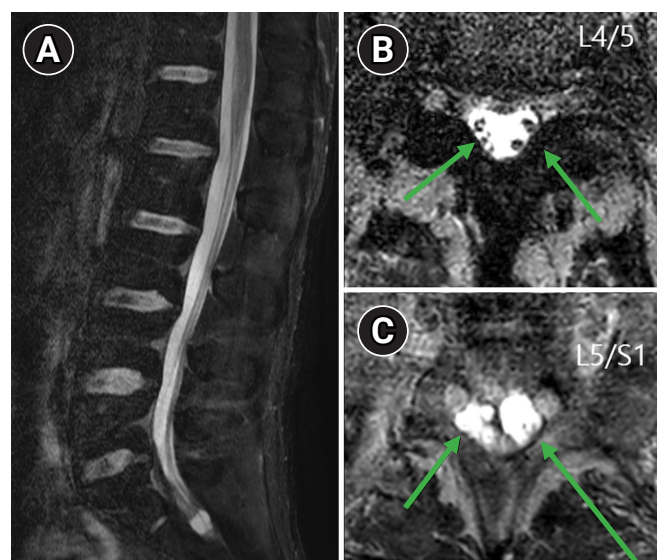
(A) Lumbar spine midsagittal magnetic resonance imaging showing fatty degeneration of the posterior back muscle at the lower lumbar spine level. (B, C) An arachnoid cyst at L4/5 through L5/S1 (green arrows).
